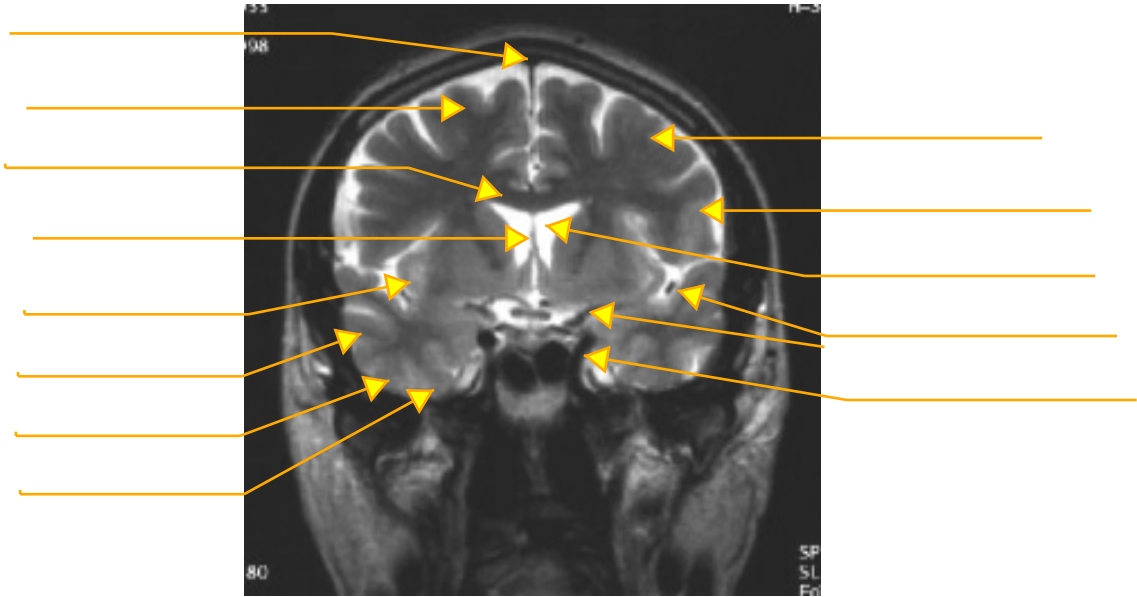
Coronal MRI (T2) through the frontal lobe.
